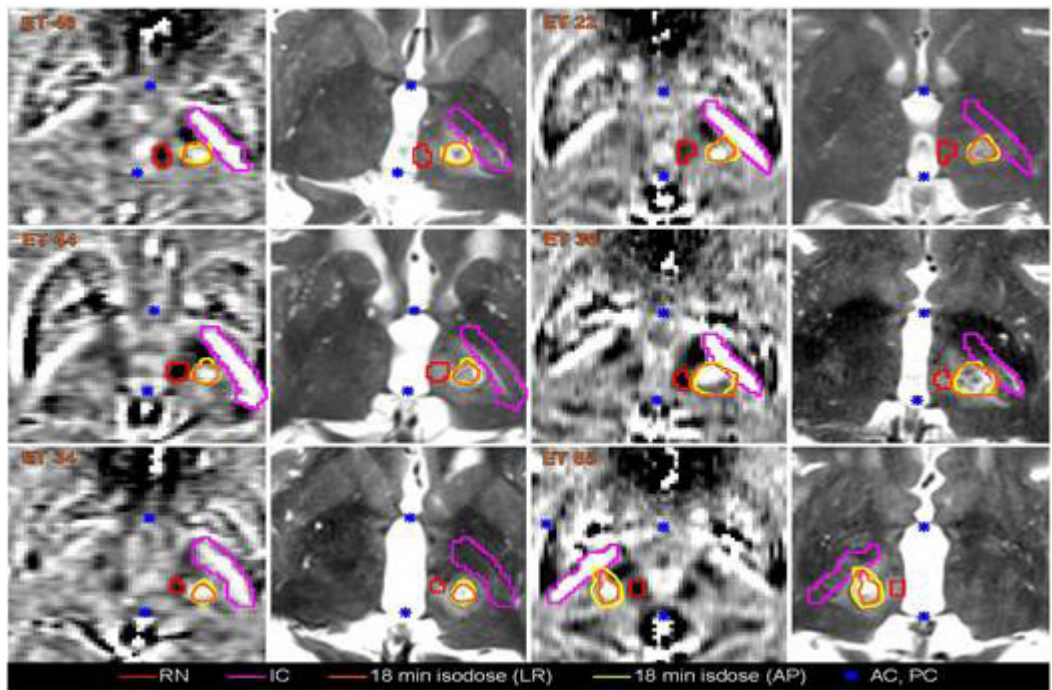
Axial phase maps (left) and T2-weighted images acquired 24 h later (right) for six ET treatments. The segmentations and accumulated thermal dose contours were generated from the same image data.
